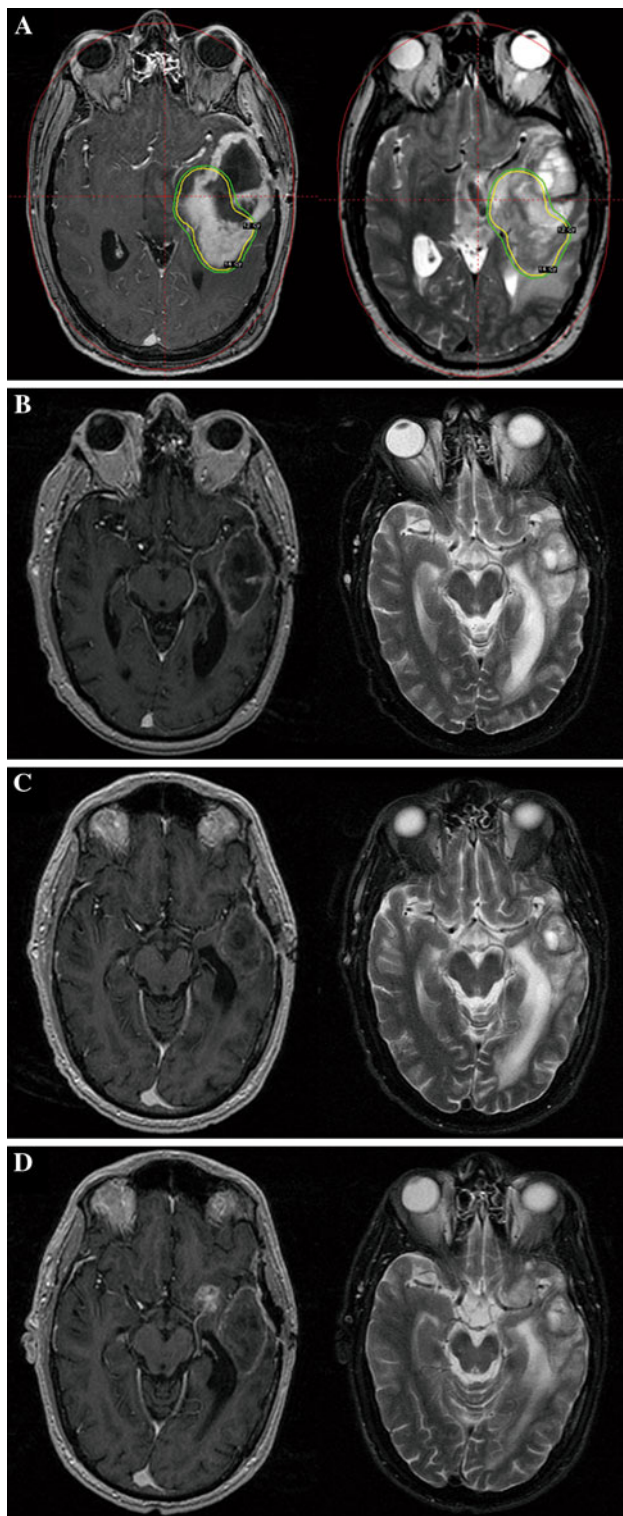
Magnetic resonance imaging (MRI) of a patient (case 1) with recurrent glioblastoma multiforme who underwent gamma knife stereotactic radiosurgery (GKSr) followed by combination treatment of bevacizumab and irinotecan. The tumor was significantly smaller after treatment (partial response). MRI scans at the time of GKSr (a), 3 months (b) and 15 months after GKSr (c). However, tumor recurrence was discovered in next follow up MRI scan (d). The patient underwent repeat GKSr for the recurrence
